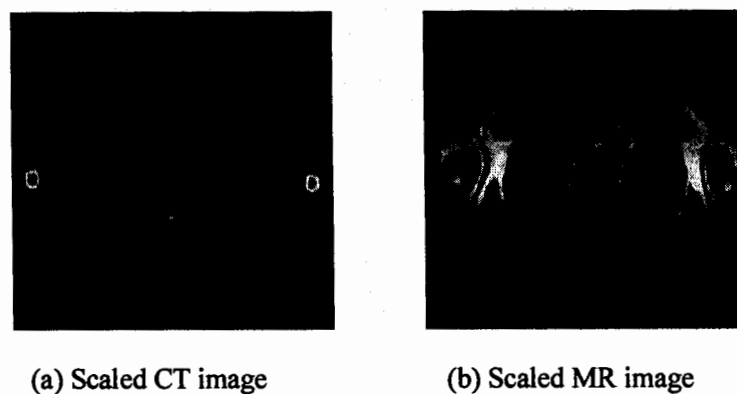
Scaled CT and MR Images of Chest by Proposed Method
